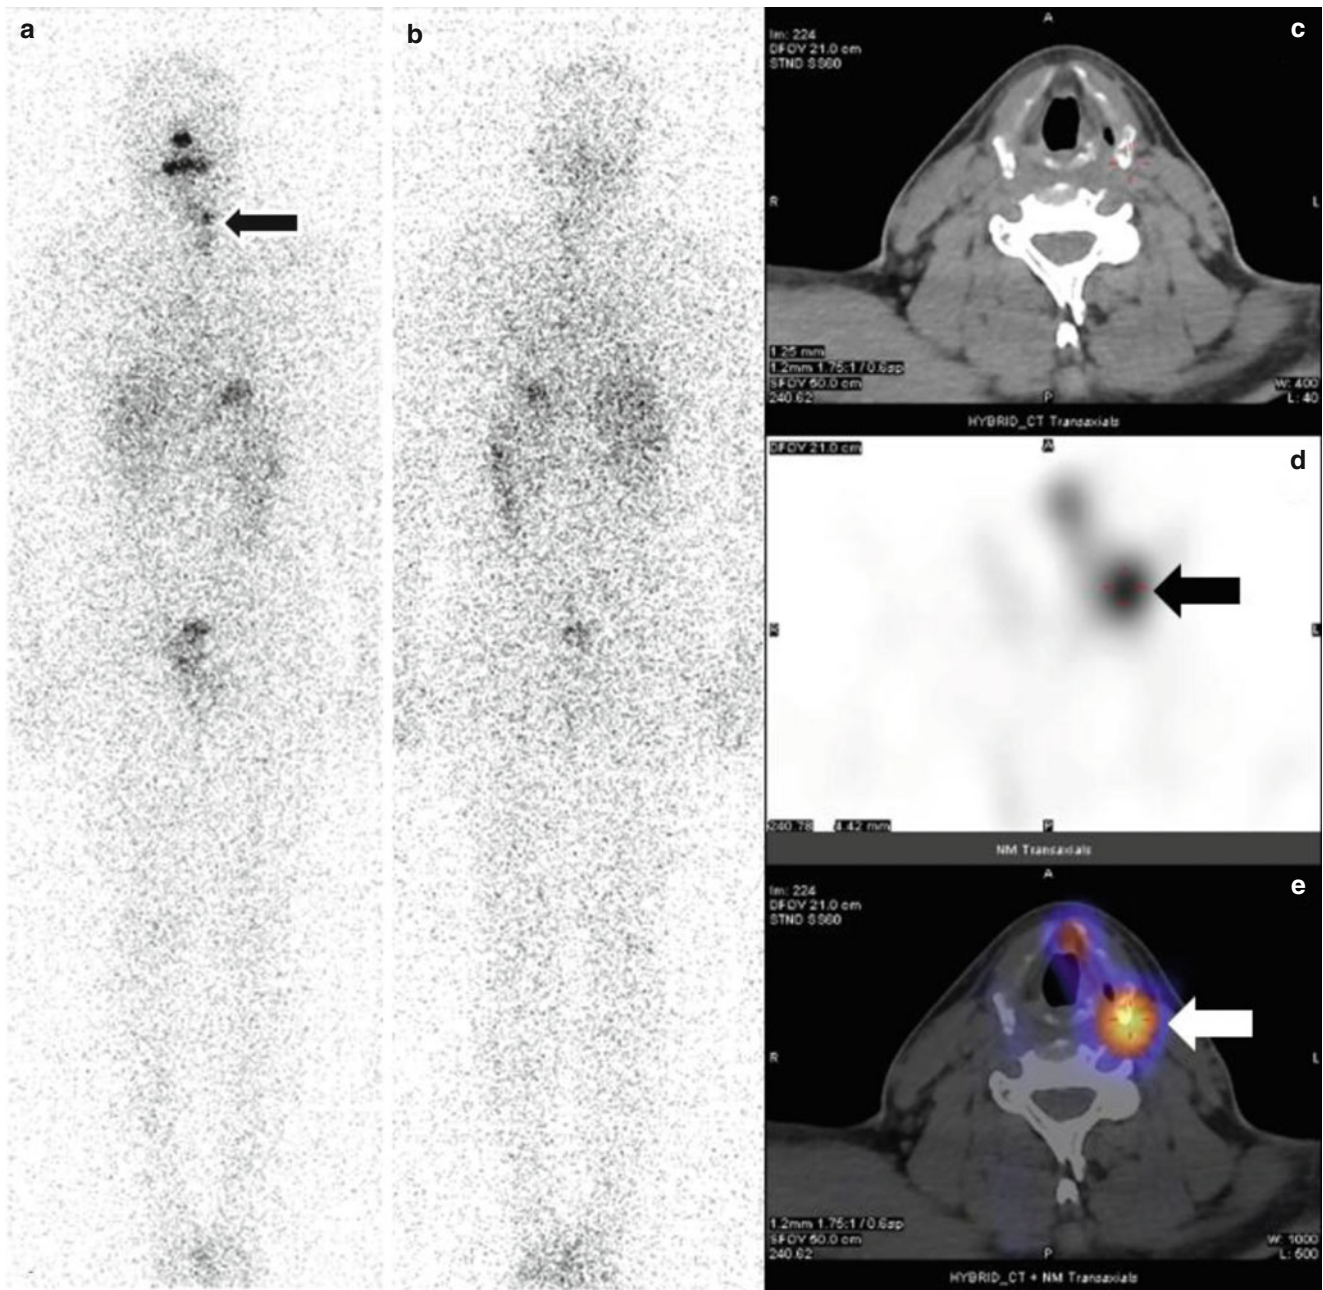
Diagnostic planar anterior (a) and posterior (b) ¹³¹I whole body images and cervical hybrid SPECT/CT (c–e) showing local recurrence (arrows) in a patient presenting with biochemical relapse of papillary
